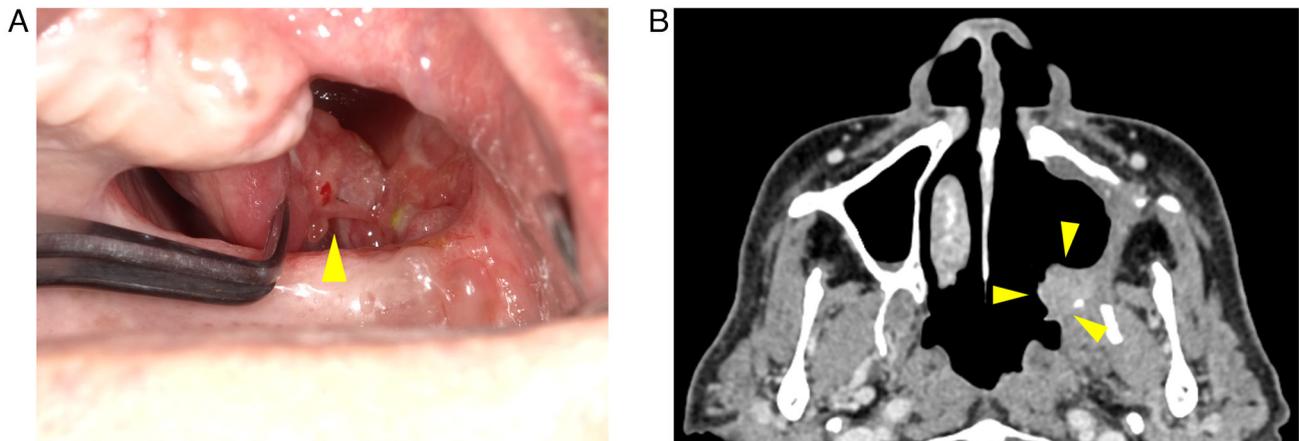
The residual tumor after six cycles of paclitaxel, carboplatin and cetuximab. (A) Intraoral photograph of the residual tumor was shown. (B) Computed tomography showed that the tumor remained only partially anterior to the pterygoid process. The arrowheads indicate residual tumor.
